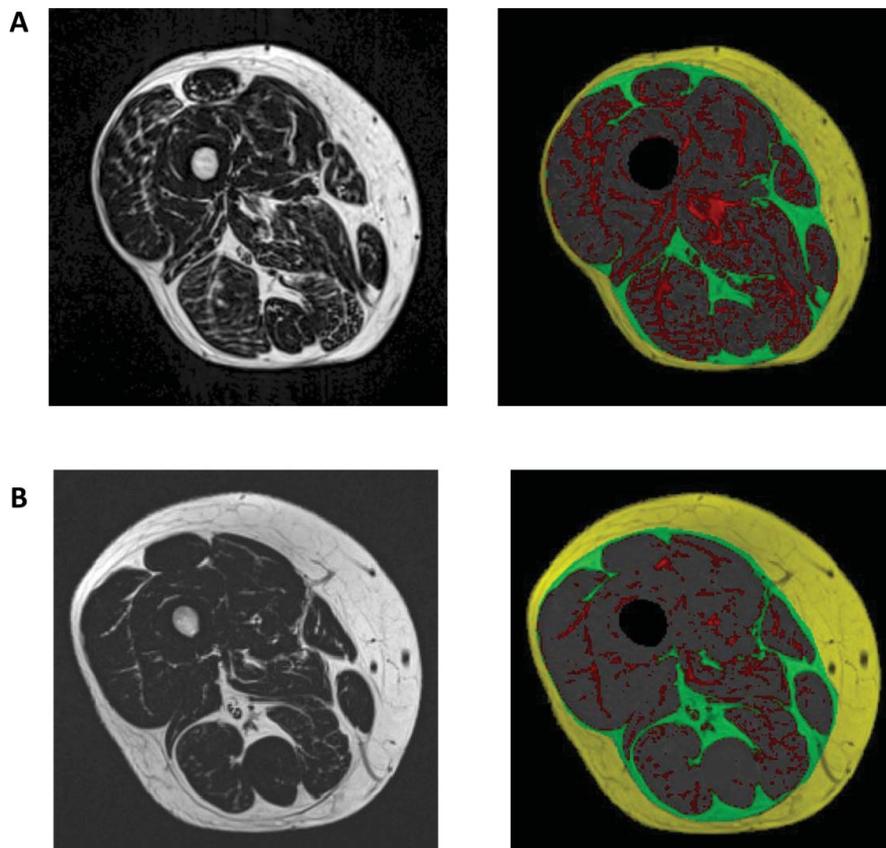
MR images of the thigh. An example of 2 subjects with similar total fat content but different distribution. T1-weighted magnetic resonance images together with color-coded masks (yellow = subcutaneous fat, green = subfascial fat/beneath the fascia, red = intramuscular fat) are presented. Subject A (total fat area 153 cm²) had considerable intramuscular fat infiltration (39% of total fat content) and a moderate portion of subcutaneous fat (43%); subject B (total fat area 149 cm²) had low intramuscular fat content (15%) and a dominant subcutaneous fat layer (64%). The content of subfascial fat was similar (18% in subject A and 21% in subject B).
